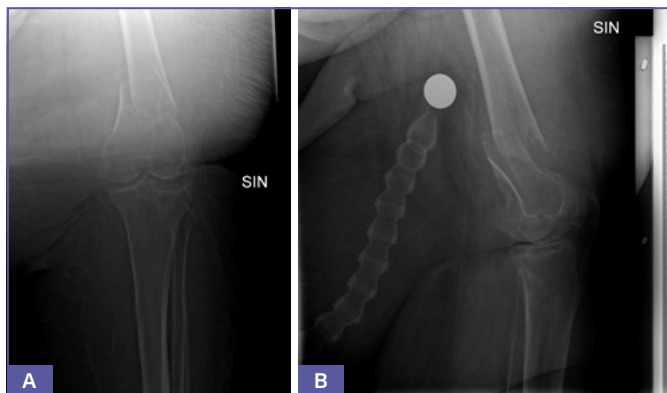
Pre-operative X-ray of the supracondylar femur fracture.
